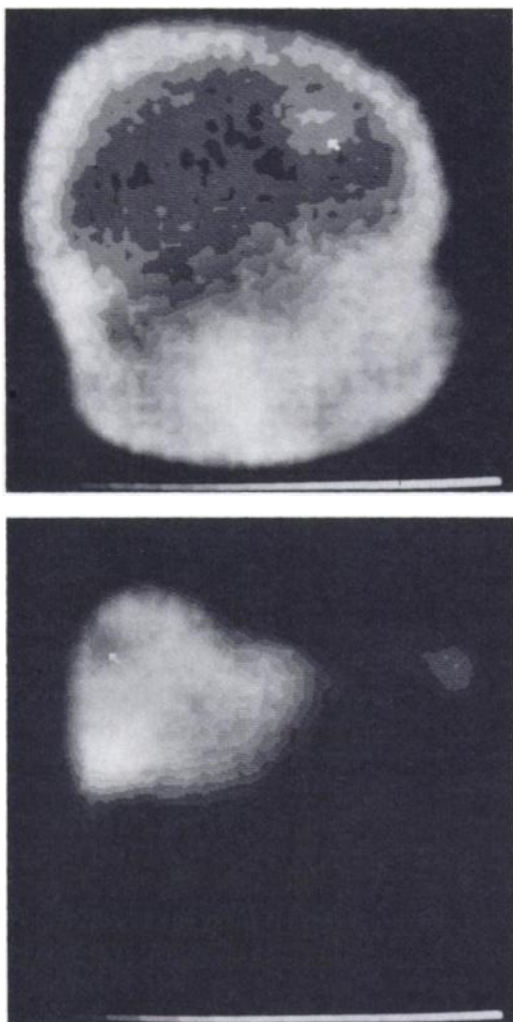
Typical brain (top) and liver scintigrams are shown using "white-on-black" display. Superimposed lesion is indicated by arrow in each case.
